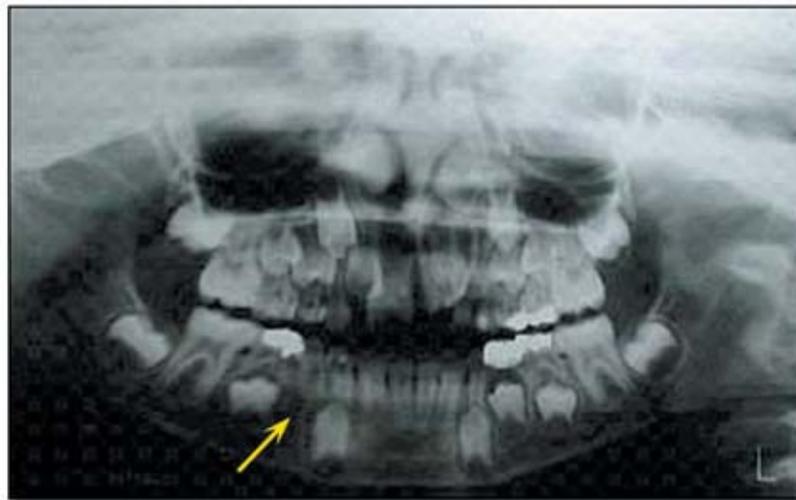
Pre-treatment orthopantomograph. (Arrow indicates the congenitally missing Tooth #44 FDI.)
